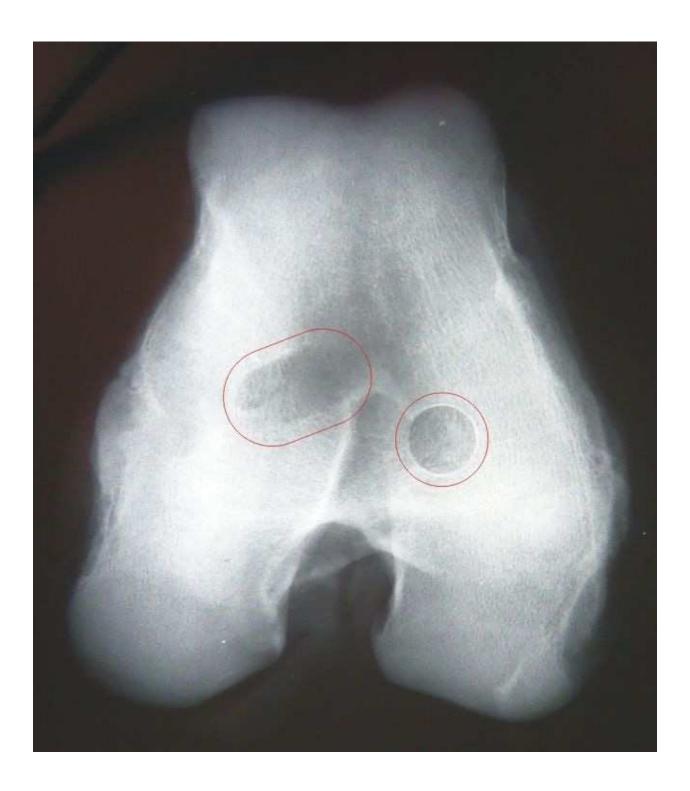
X-ray analyses of the encapsulated COC-blend replacements in the subchondral bone by collagen (I. type)
